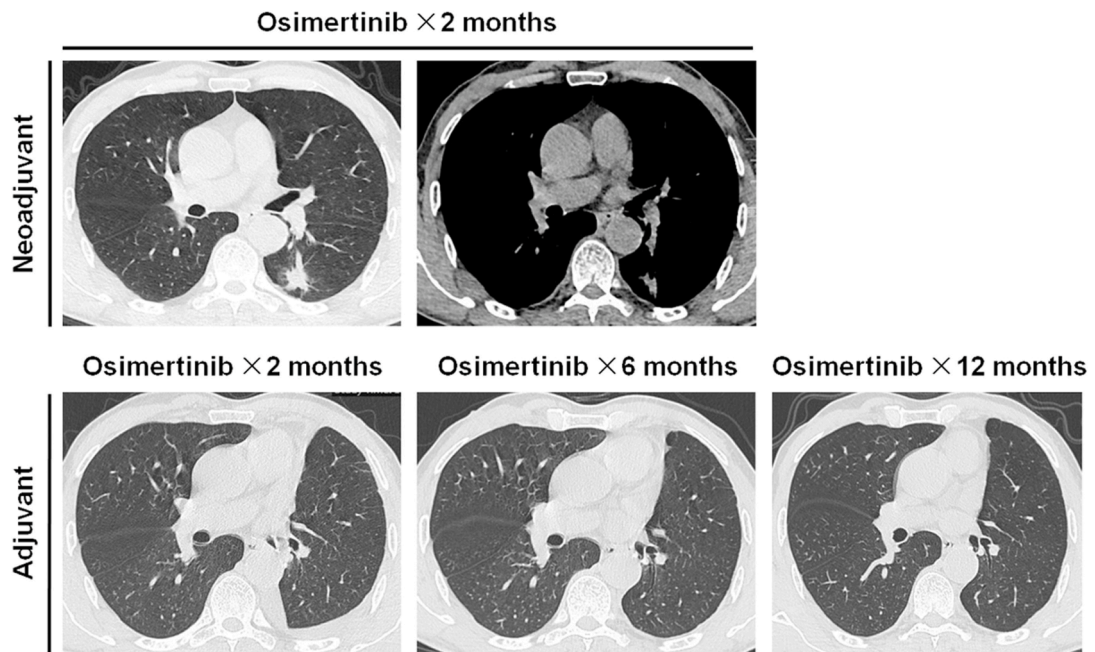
Radiologic evaluation of Osimertinib neoadjuvant and adjuvant therapies. The patient with EGFR mutant stage IIIA (T2aN2M0) NSCLC was treated with Osimertinib neoadjuvant therapy for 2 months. Repeated chest CT examination suggested a significant PR of the primary tumor and downstaging of metastatic lymph nodes (upper panel). Surgical resection was performed and the post-operative clinical stage was IA3 (pT1cN0M0). Targeted therapy with Osimertinib was continued in adjuvant setting and chest CT evaluation in our follow-ups indicated no evidence of disease recurrence.
